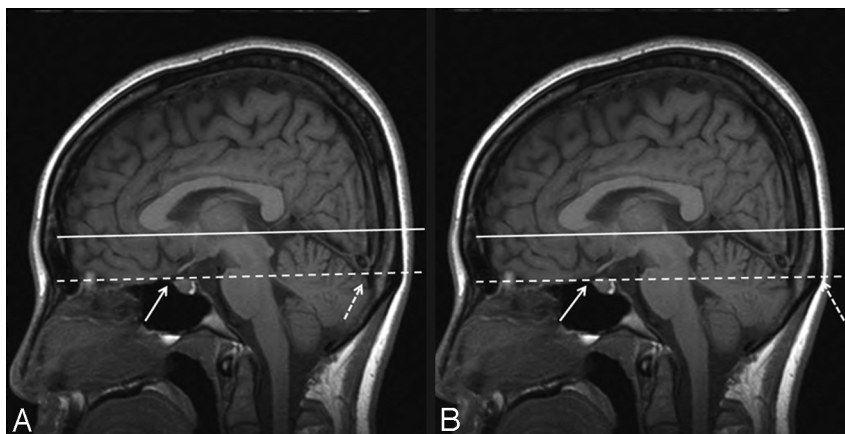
The TS-IOP and TS-EOP lines in the midsagittal T1-weighted image. *A*, The TS-IOP line (dashed line) connects the tuberculum sellae (straight arrow) and the internal occipital protuberance (dashed arrow). The straight line represents the ACPC line that connects the anterior commissure and the posterior commissure. *B*, As shown in *A*, the TS-EOP line (dashed line) connects the tuberculum sellae (straight arrow) and the external occipital protuberance (dashed arrow). The TS-IOP and TS-EOP lines run nearly parallel to the ACPC line.
